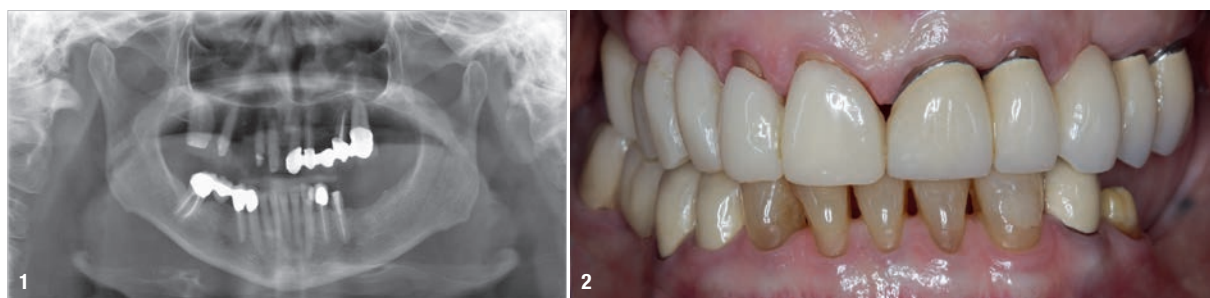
Panoramic radiograph of the initial situation. Fig. 2: Preoperative situation, frontal view.
